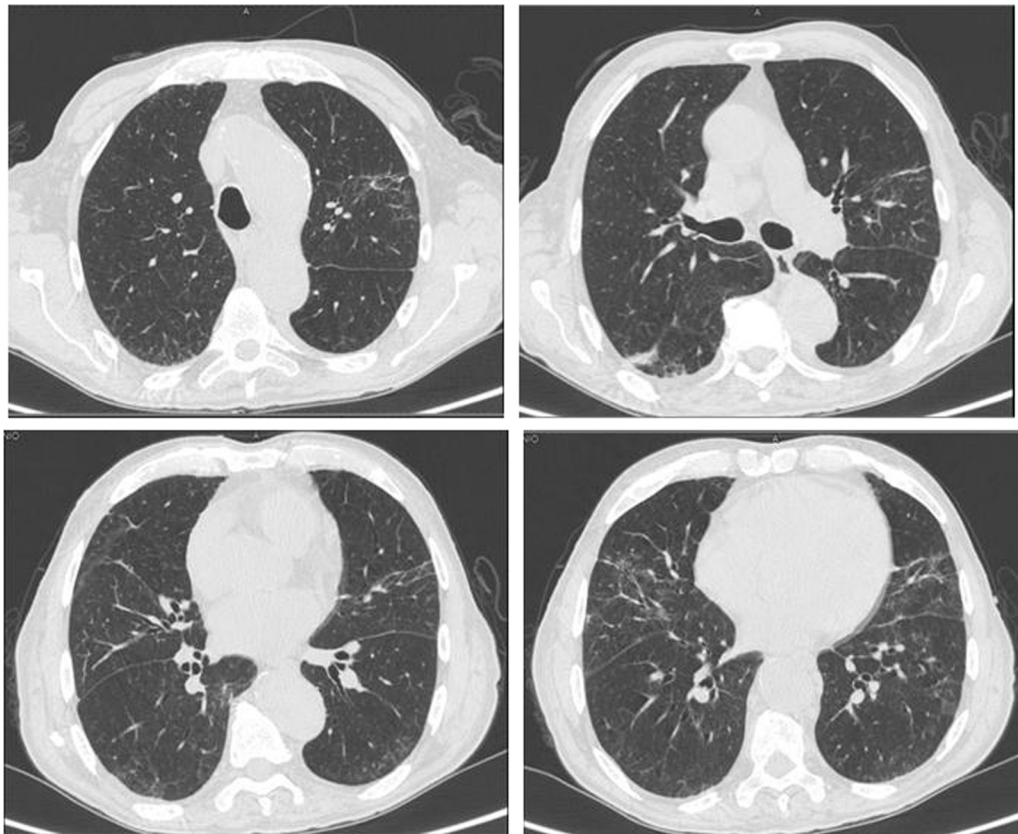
Chest CT scan after treatment with itraconazole. A prominent reduction of ground glass opacities and consolidation in all involved lobes were observed.
